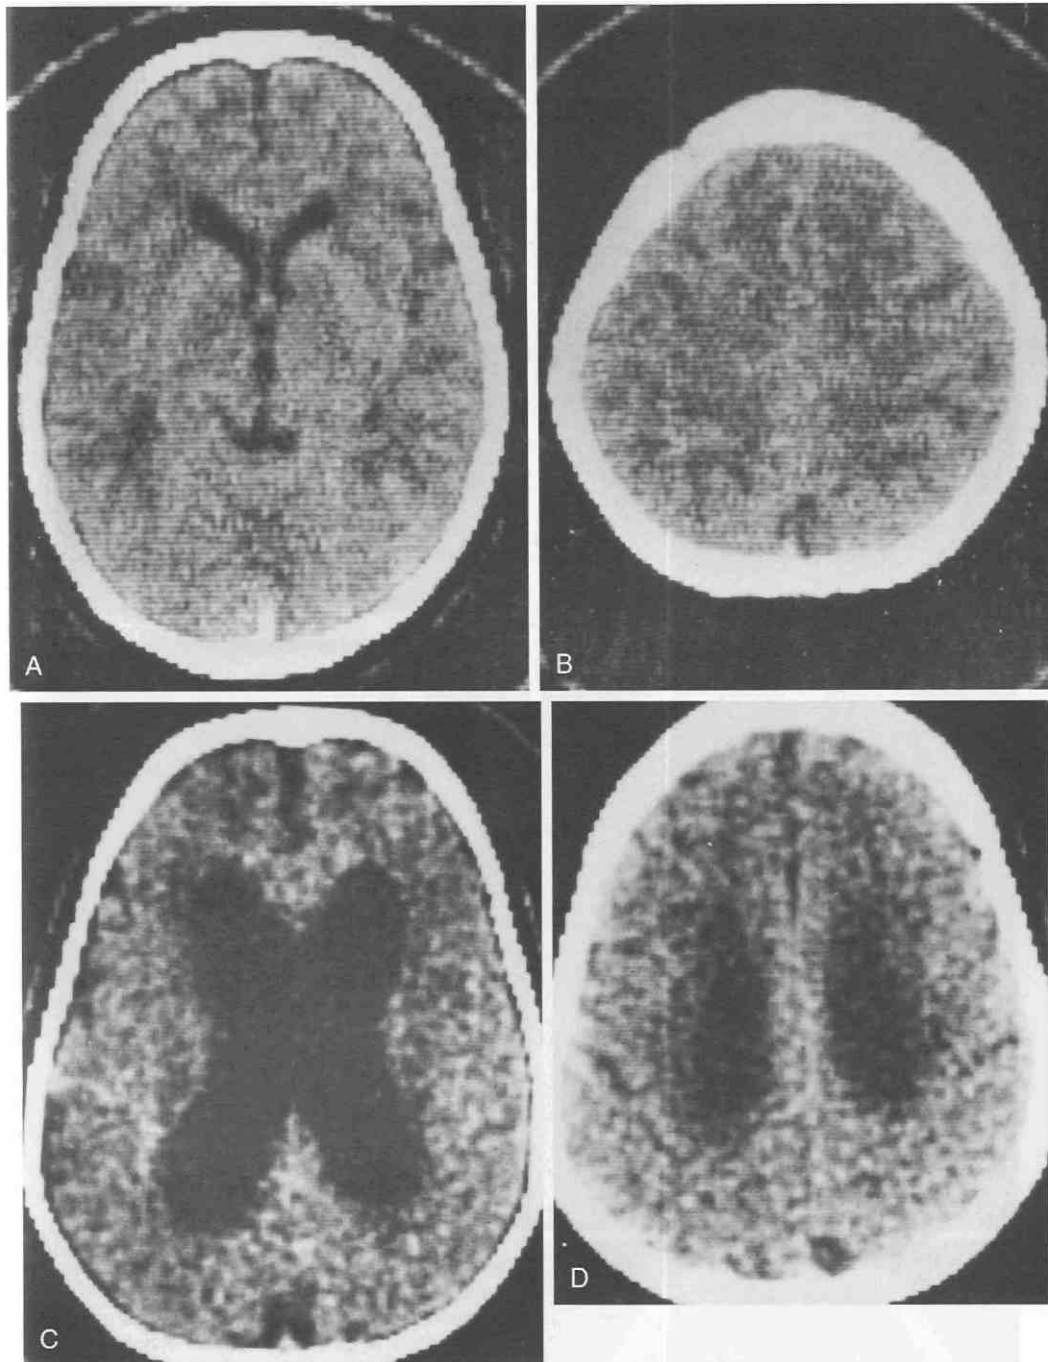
Spongiform encephalopathy (Canavan's disease). *A* and *B*, CT scans of a 2½-year-old boy with progressive neurologic deterioration and an enlarging head. There is diffuse, symmetrical, generalized lucency of the white matter. *C* and *D*, A repeated CT scan performed 2 years later, when the patient was 4½ years old and in a vegetative state. Significant ventricular dilatation has supervened. The white matter has become shrunken, resulting in central cerebral atrophy. At this final stage of the disease, the CT appearance is nonspecific. (A–D, From Moss AA, Goldberg I [eds]: *Computed Tomography, Ultrasound, and X-ray: An Integrated Approach*. San Francisco, University of California, San Francisco, Department of Radiology, 1980.)
